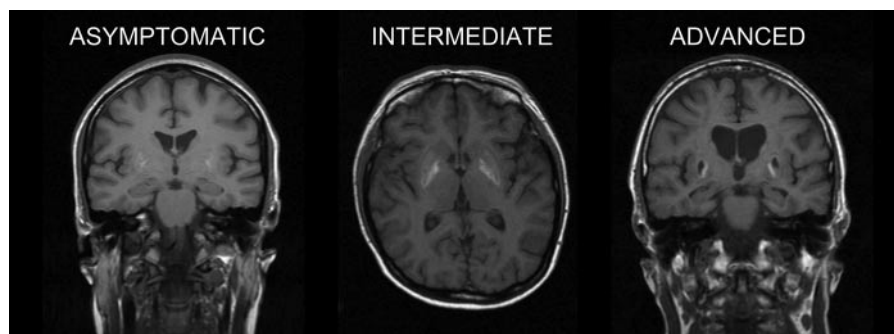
Brain magnetic resonance imaging in neuroferritinopathy. T₁ weighted images acquired on the same subjects as shown in Fig. 2. *Left hand panel:* faint increase in T₁ signal in the putamen bilaterally in the asymptomatic case (Case 1). *Middle panel:* more prominent signal increase in the periphery of the putamen and globus pallidus in the intermediate case (Case 12). *Right hand panel:* prominent peripheral signal increase surrounding the cystic degeneration of the putamen and globus pallidus in the advanced case (Case 35).
